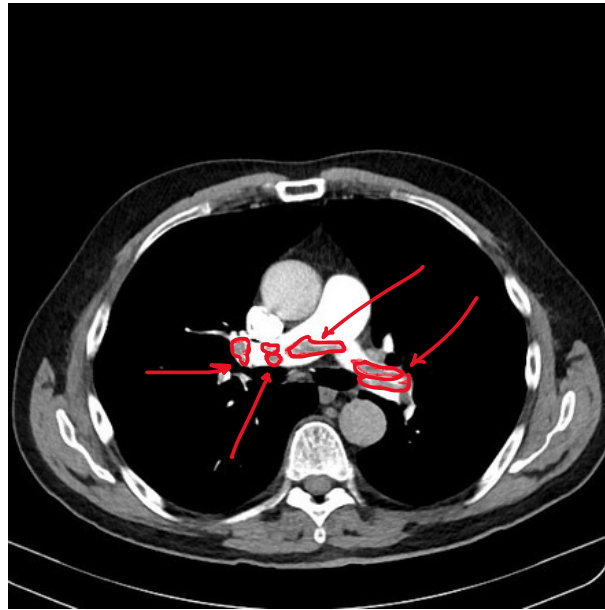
CT with PE in the pulmonary trunk. PE can be distinguished inside the 'filling defects' in the pulmonary trunk.
